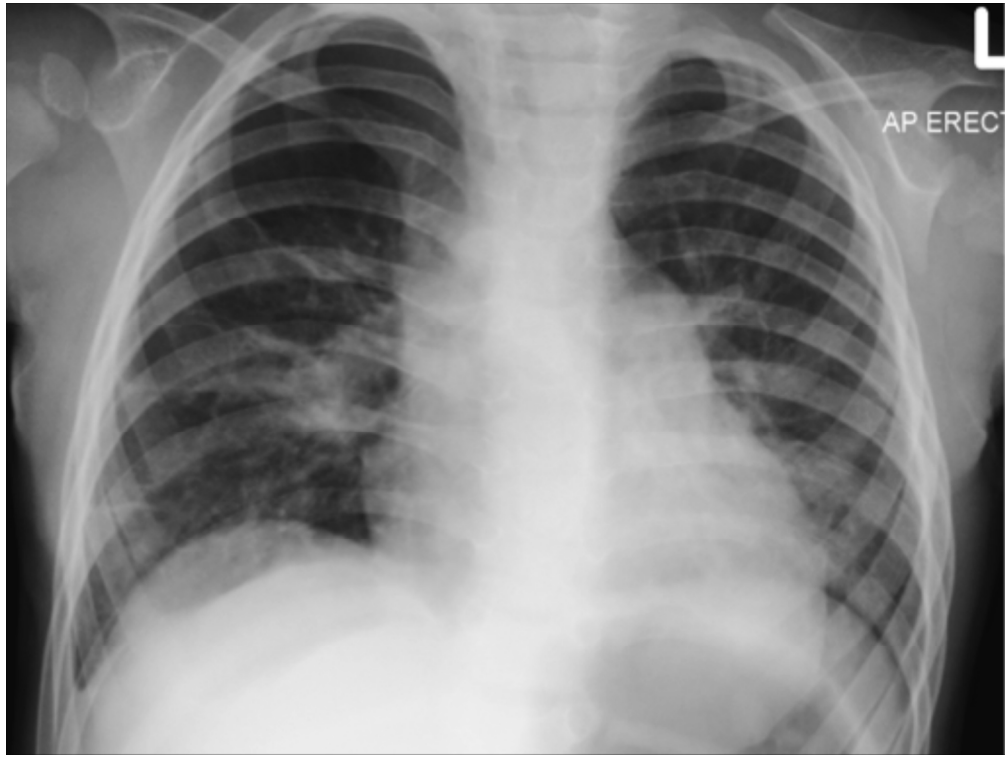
Chest radiograph of patient in case 4 performed at 8 months of age demonstrates right upper lobe hyperinflation and atelectasis within the right midzone and left lower lobe.
